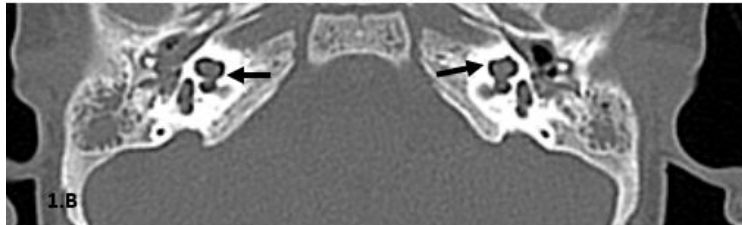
B: Axial CT bone window revealed bilateral cochlear cystic malformed apex (black arrows).
